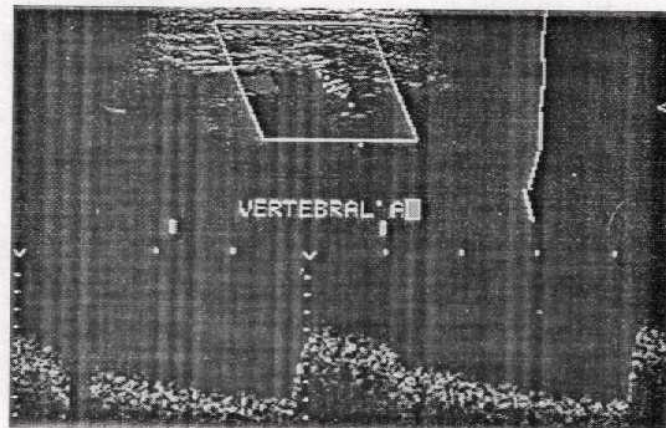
Doppler spectral wave form a normal vertebral artery (*Quoted from Taylor., 1995*).
